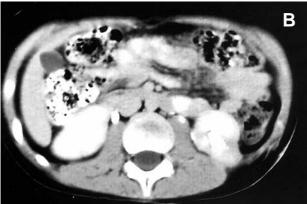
Juvenile dermatomyositis. A) Postoperative intravenous pyelogram revealing satisfactory urinary flow without ureteral dilation. B) Postoperative CT scan revealing a small calcification in the left psoas muscle and left ureter, without dilation.
